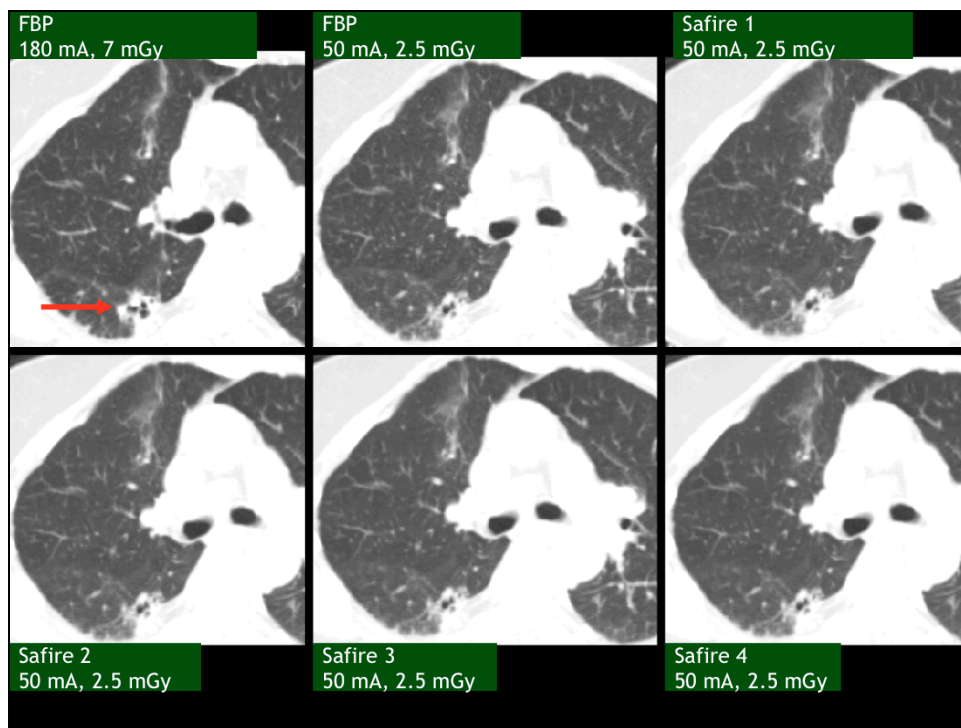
Transverse chest CT images showing solid and cystic opacity in the right lower lobe with bro
